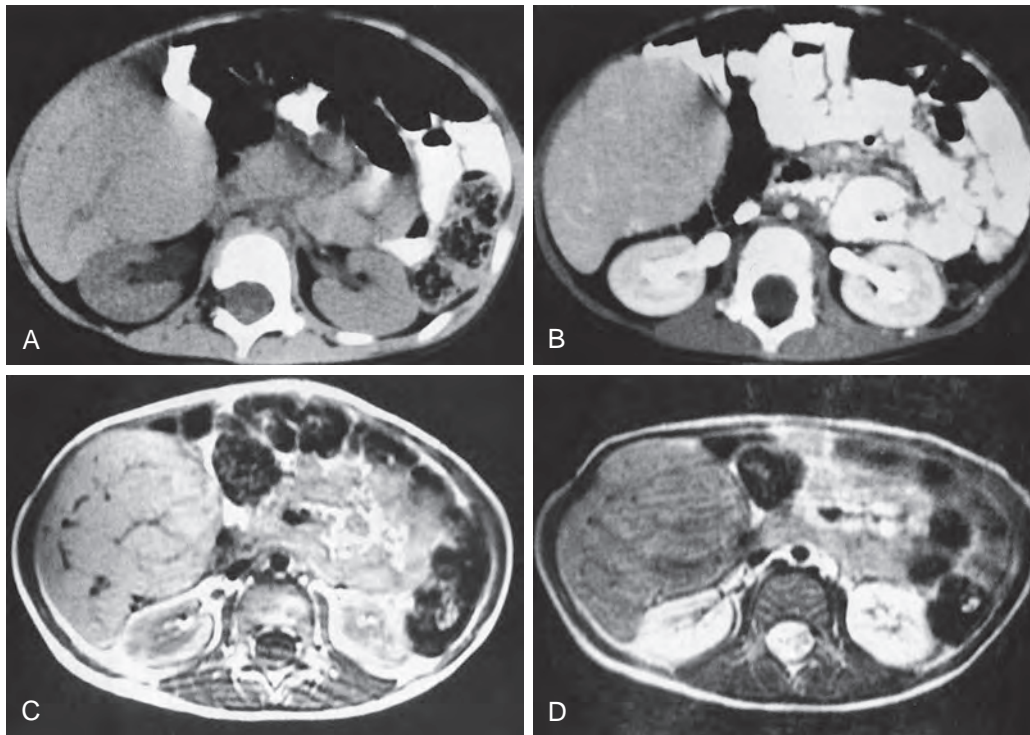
Focal nodular hyperplasia. The newborn was found to have an enlarged liver on physical examination. CT images reveal a round mass in the inferior aspect of the right lobe that has the same density as surrounding parenchyma before (A) and after (B) contrast enhancement. MRI reveals a signal intensity equal to that of surrounding parenchyma on T1-weighted (600/30) (C) and T2-weighted (2000/80) (D) sequences.
